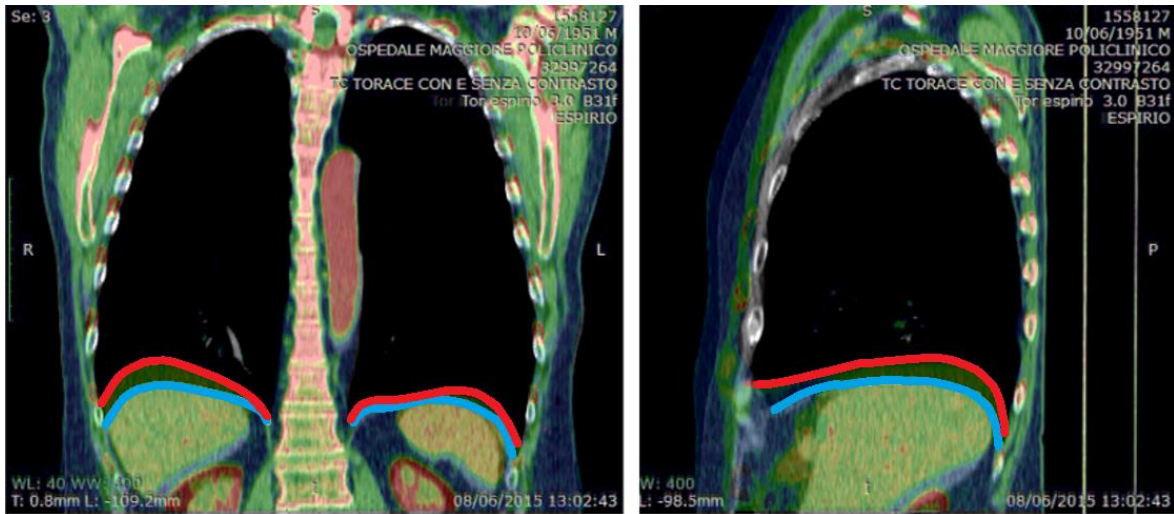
Overlapping of CT images taken at TLC (green) and RV (red) of a COPD patient.
